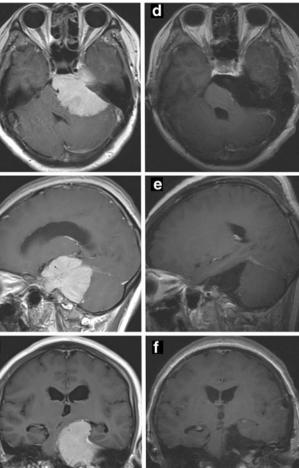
Case 4: pre- (a–c) and post-operative (d–f) magnetic resonance imaging. A female patient was 41 years old with a preoperative KPS score of 60. The tumor was  $5.3 \times 5.3 \times 6.4$  cm in size. The presigmoid approach was selected to completely remove the lesion. The patient suffered CN V and VII dysfunction, and her other symptoms were unchanged—as was her postoperative KPS score of 60. At the latest follow-up (38 months after surgery), she had noticeably recovered. She was able to work full time and perform household duties, with a most recent KPS score of 90. *CN* cranial nerve, *KPS* Karnofsky Performance Scale
